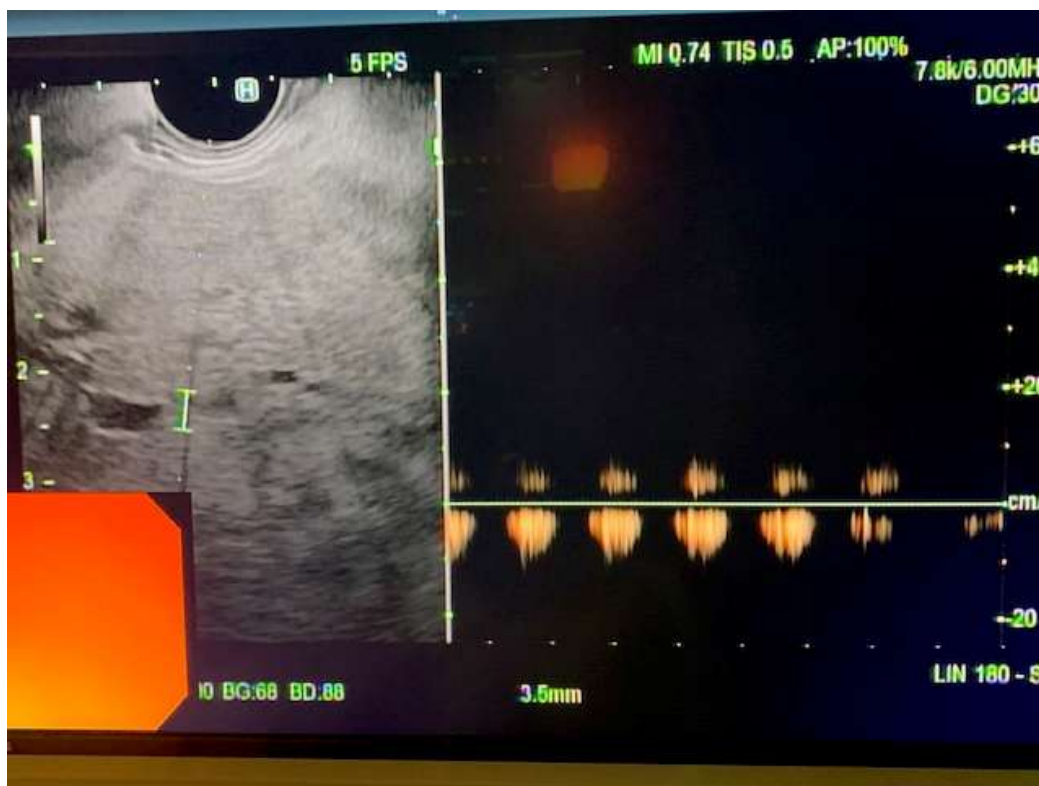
Pulse wave Doppler of the middle hepatic vein.
